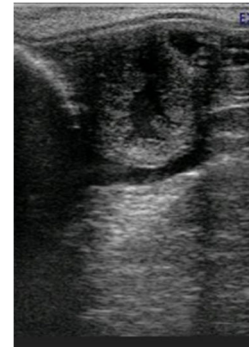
Ultrasonogram of left uterine horn of a mare following cyst ablation
